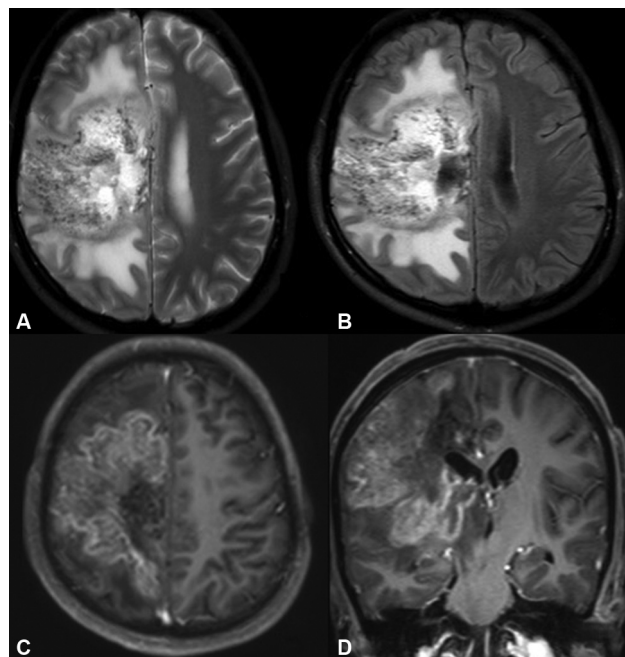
(A, B) MR brain T2-weighted axial imaging showing hyperintense lesion involving the right frontal and parietal lobe with areas of microbleeds. There is extensive perilesional edema with mild mass effect. (C, D) T1-weighted axial and coronal images with contrast showing diffuse heterogeneous enhancement with the involvement of gray and white matter. There is evidence of subcortical extension into the insula and periventricular white matter. There are areas of necrosis within the lesion. Imaging features favor a mass lesion, high-grade glioma.
